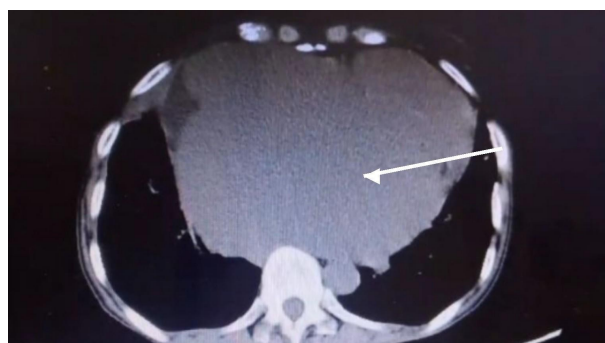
Contrast-enhanced CT of the chest showing giant left atrial enlargement causing posterior mediastinal mass effect with anterior displacement and compression of the thoracic esophagus (white arrow).
